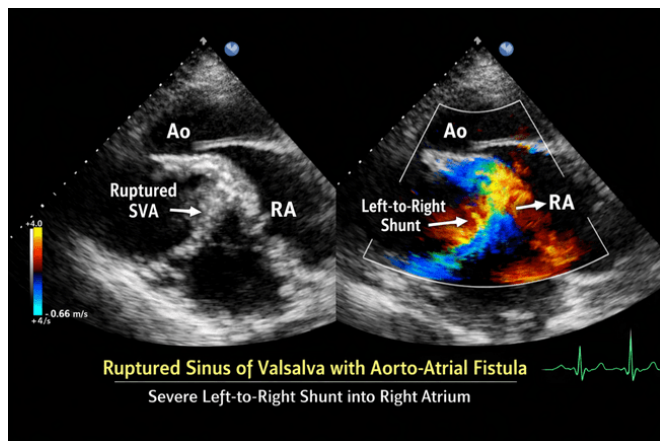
Transthoracic echocardiography demonstrating a ruptured sinus of Valsalva aneurysm originating from the non-coronary sinus with fistulous communication into the right atrium. The arrow indicates the aneurysmal windsock structure and turbulent left-to-right shunting from the aorta into the right atrium.
